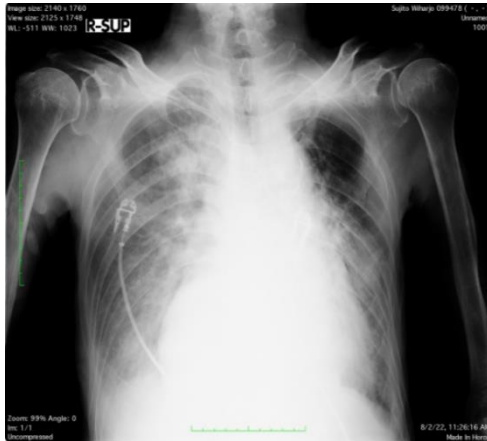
Photo of PA/AP Thorax X-ray Adult initial S. 84 years old
